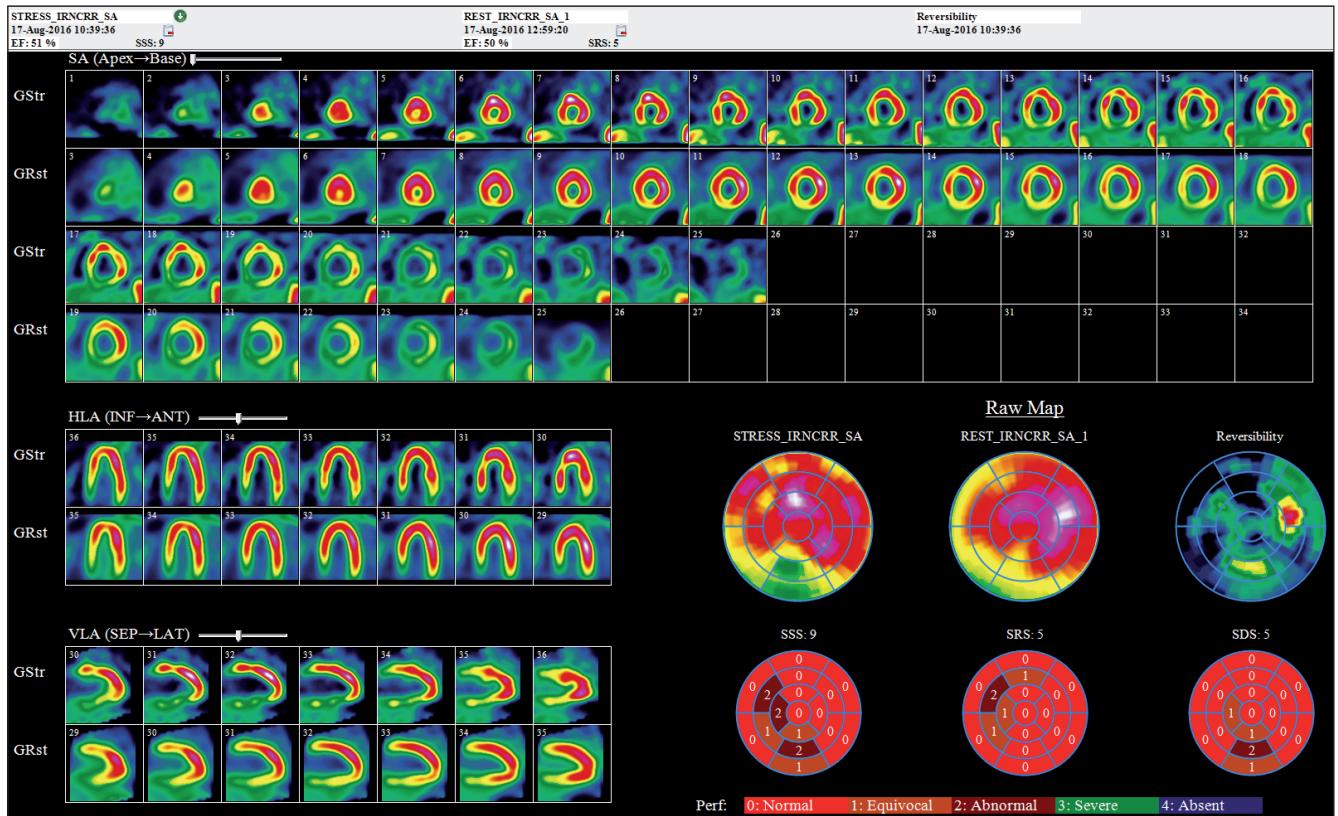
SPECT examination with the finding of signs of ischemia in the area of the inferior wall.
